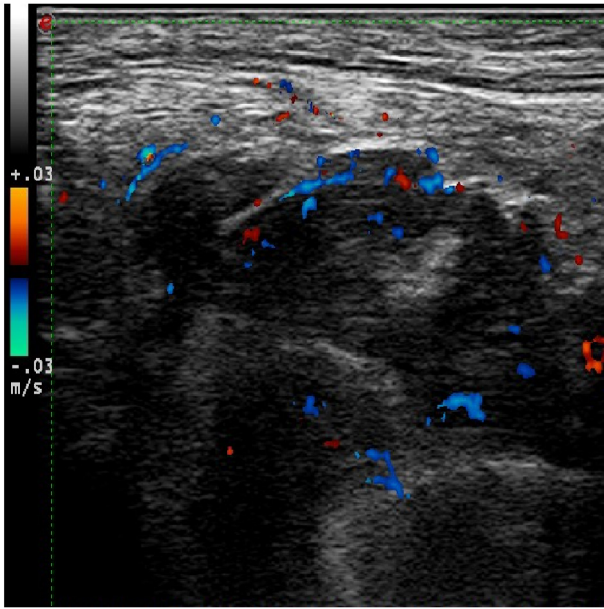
B-ultrasound showed a low-echo dark area under the left perianal skin, with thick internal fluid and obvious blood flow signals.
